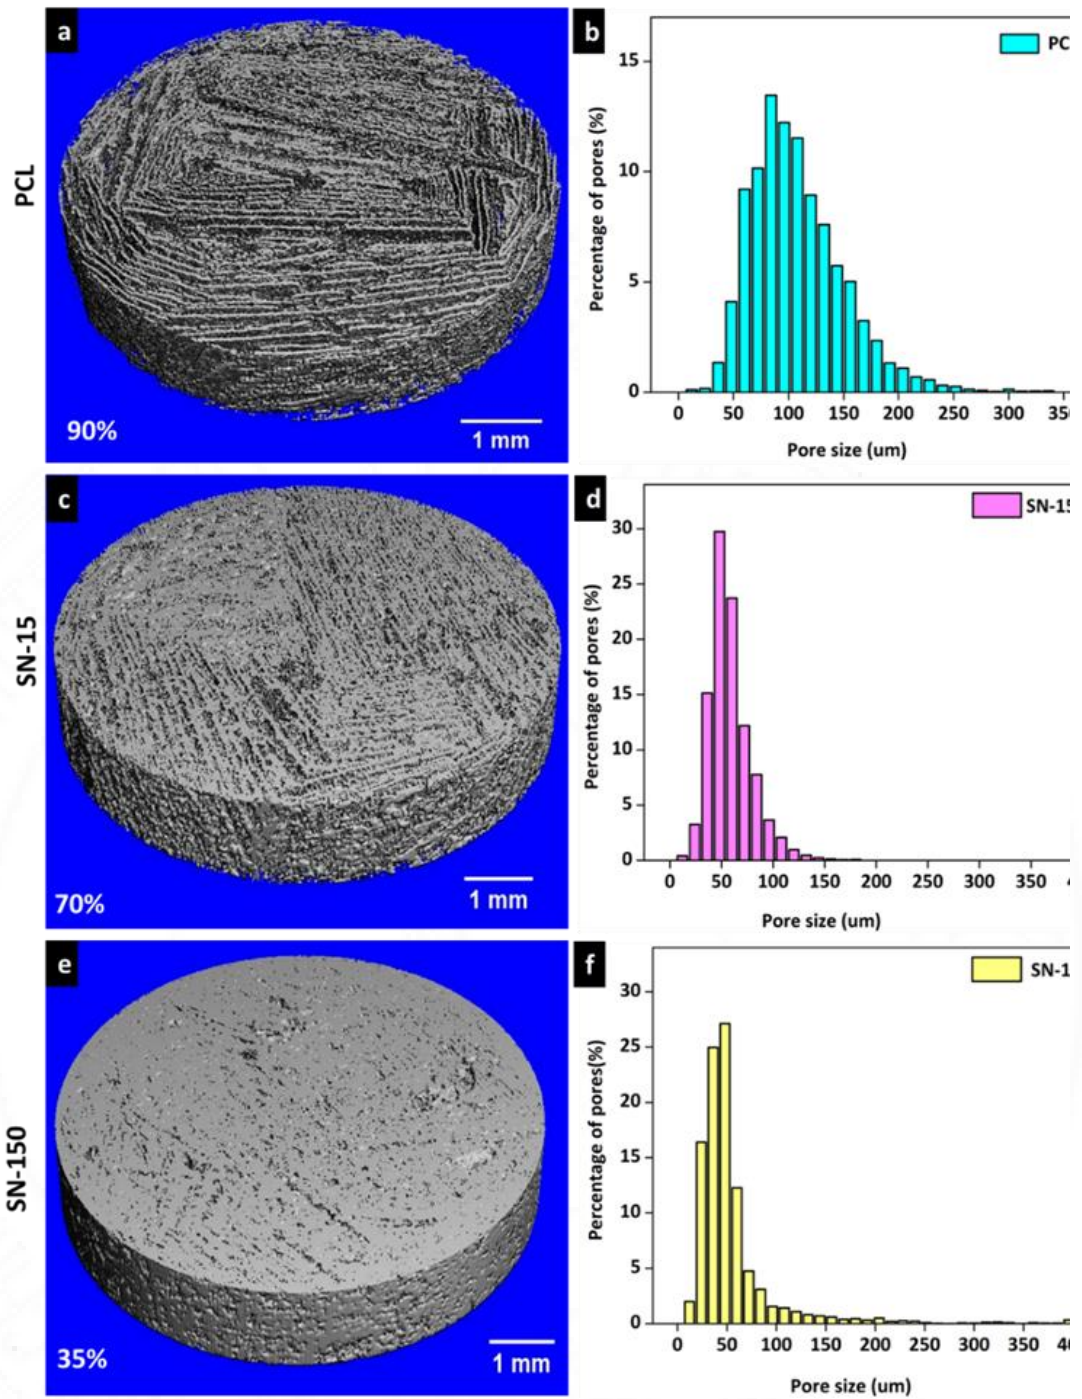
Micro CT images and pore size distribution of PCL, SN-15 and SN-150 scaffolds. Scale bar represents 1 mm.
